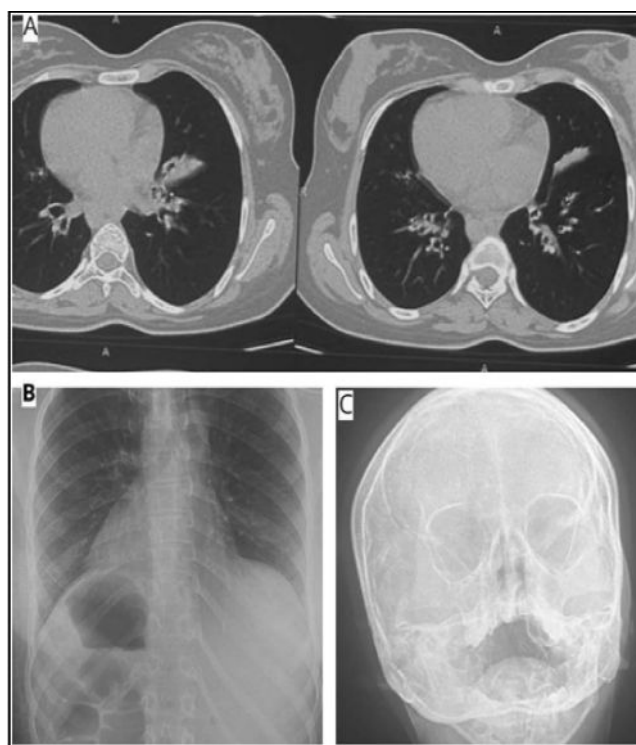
(A) CT Chest: Lung parenchyma showed bronchiectatic changes in posterior basal segments of left lower lobes. (B) Chest X ray showed dextrocardia with gastric bubble on right side and liver on left side. (C) PNS X-ray showed mucosal thickening in both maxillary sinuses suggestive of bilateral maxillary sinusitis.
